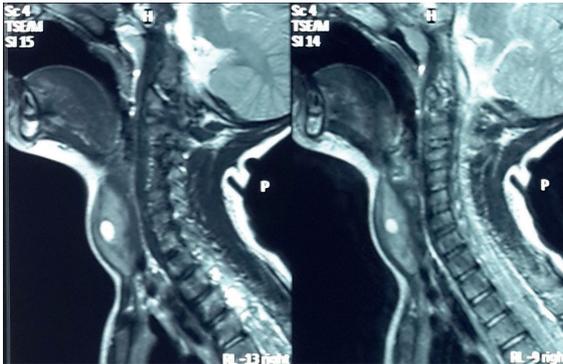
Magnetic resonance imaging section of the neck.
